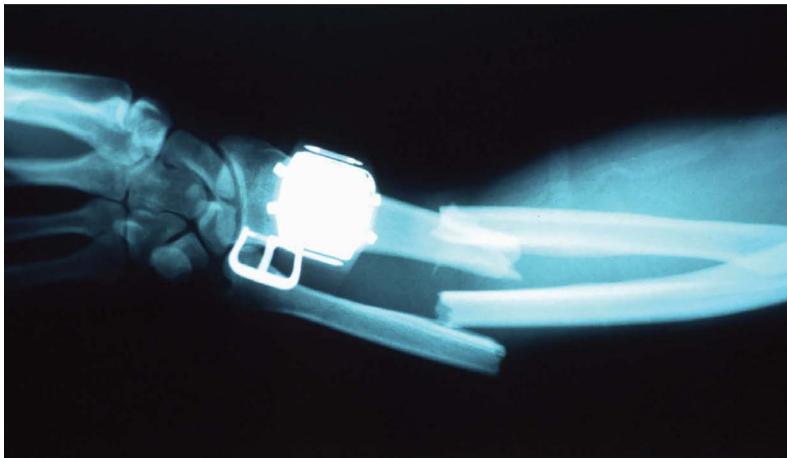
Radiograph of a forearm fracture (see Figure 3.35). The x-ray shows a fracture-dislocation of the left forearm. This injury was most likely caused by a baseball bat when the victim used his arm to shield himself from blows, also referred to as a "nightstick fracture." The victim also suffered a fatal skull fracture, most likely from the baseball bat.
